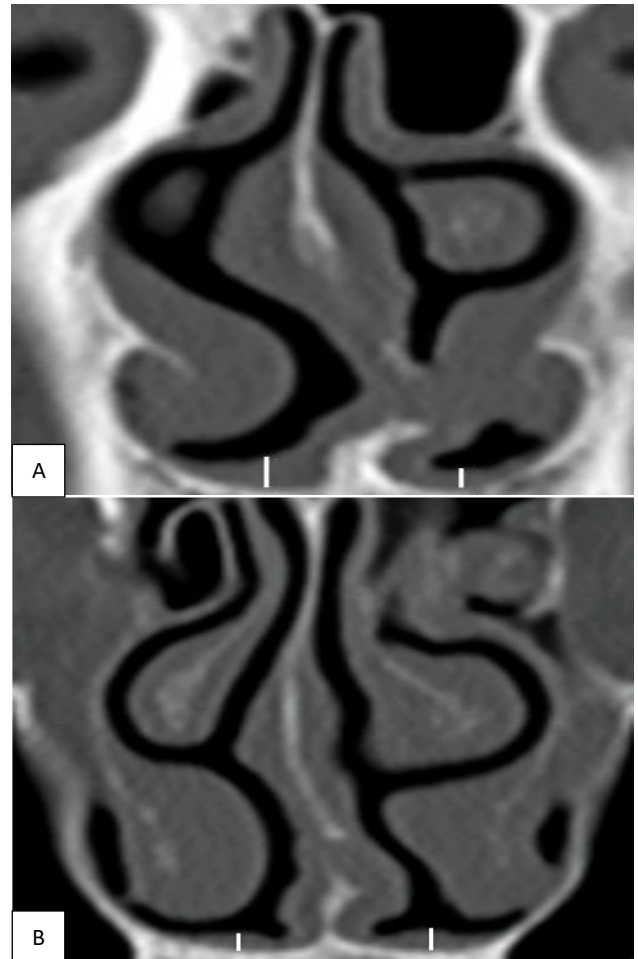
Coronal CT depicts (A) the anterior and (B) posterior nasal floor mucosal thickness.
